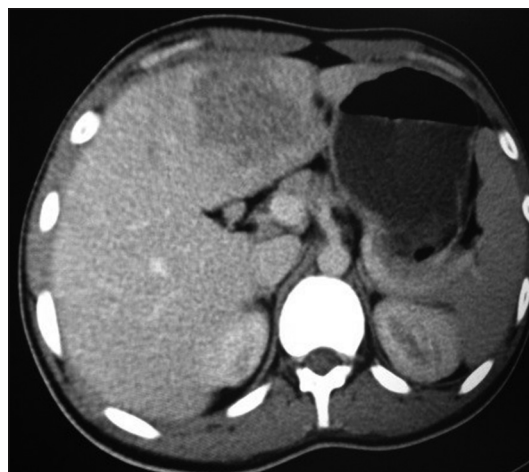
CT abdomen of the patient
